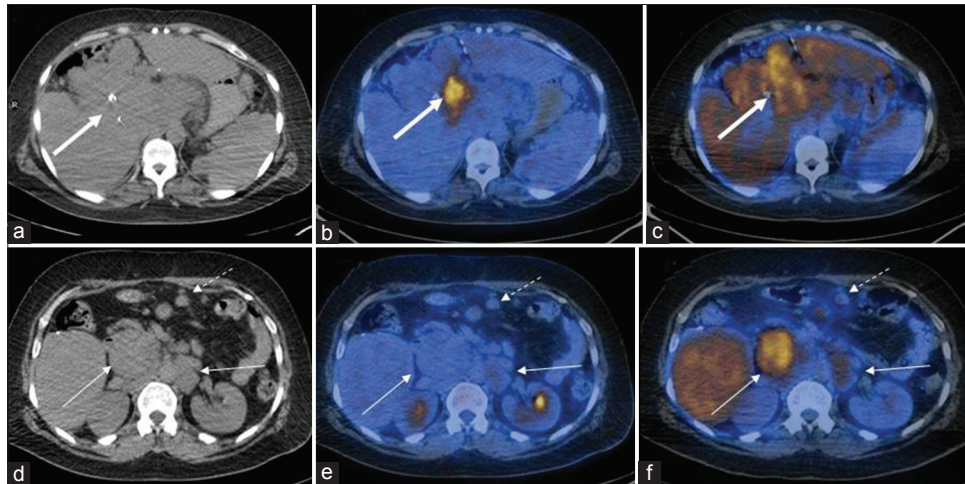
Transaxial CT (soft-tissue window) at the operative site (a), with corresponding FDG (b) and ^{11}C methionine (c) PET/CT fusion images showing recurrent hepatic mass (thick arrows). Transaxial CT (d) reveals retroperitoneal lymph nodes (thin arrows) and mesenteric (dotted arrows) lymph nodes, which do not show significantly increased FDG avidity (e), but show increased ^{11}C methionine uptake (f). CT = Computed tomography, FDG = Fluorodeoxyglucose, PET = Positron emission tomography.
